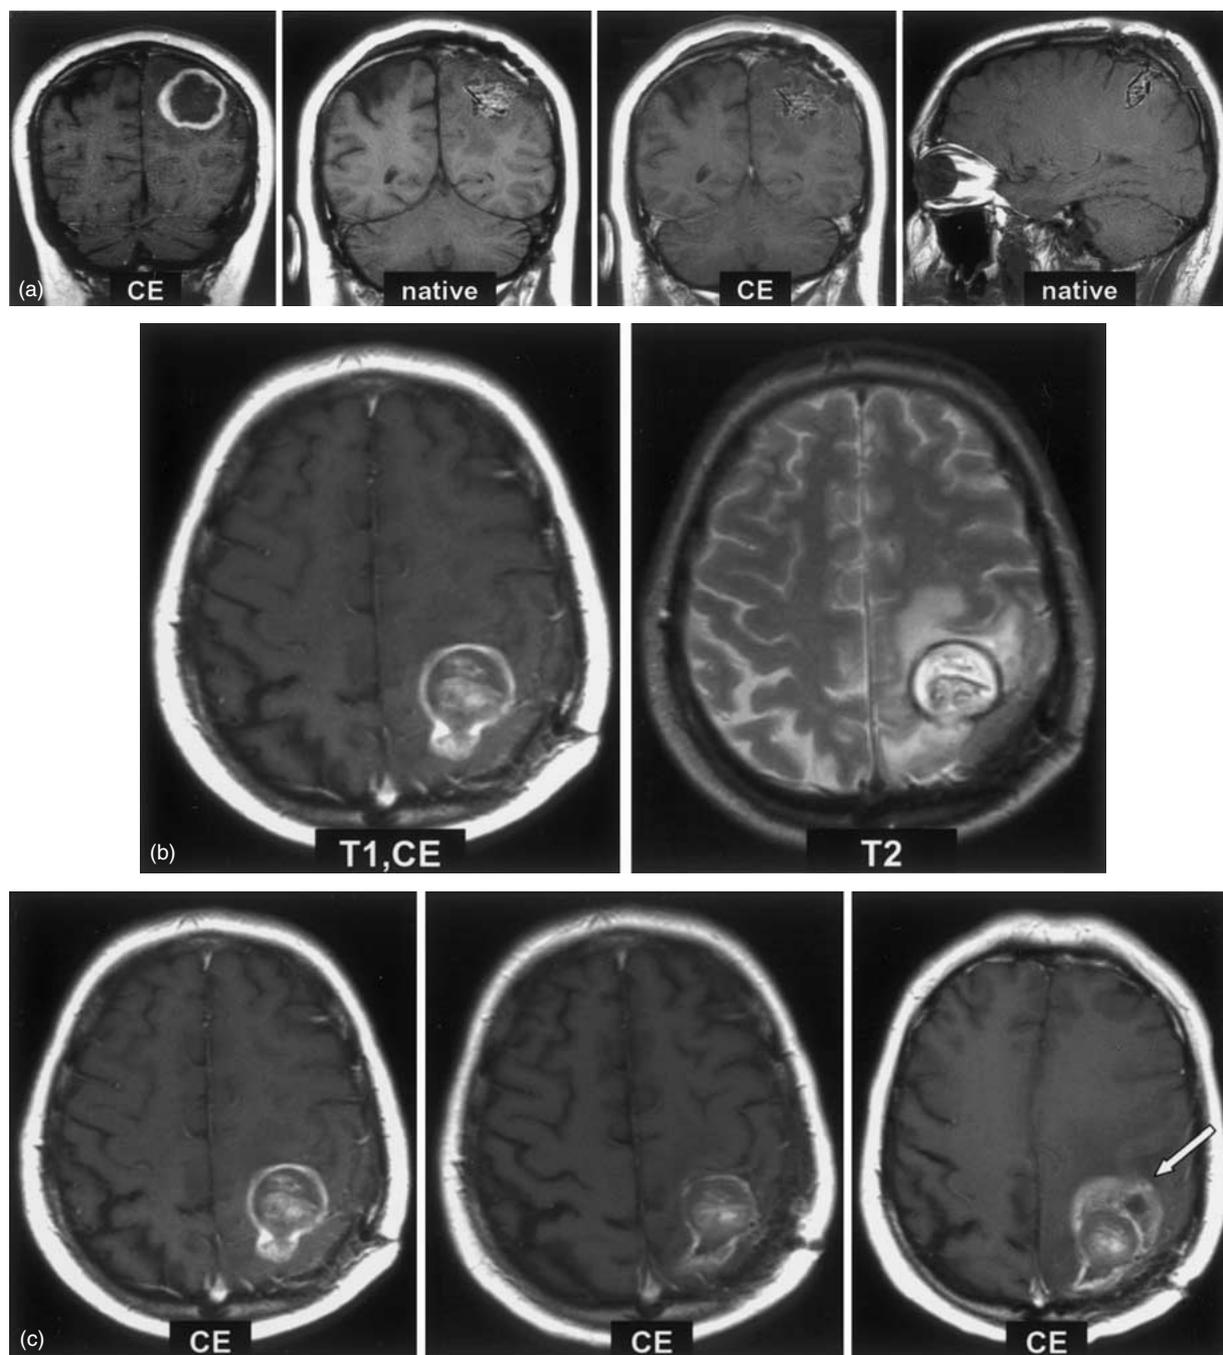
Imaging characteristics of wafer implants on MRI. (a) 45 year-old male diagnosed with a left post central glioblastoma (left image) was randomized to implantation of placebo wafers. Postoperative T1 weighted images show hemorrhagic transformation of the resection cavity without residual enhancing tumor. Wafers are visible as signal free, platelet shaped structures placed adjacent to the resection margins. (b) At 3 months post OP, enhancement of the resection margin is prominent. Remnants of incompletely resorbed blood degradation products and wafer material are noticeable in the center of the cavity, now showing a cystic configuration. Methemoglobin, causing a clear signal decrease, is also located at the resection margins forming a dark ring in the T2 weighted image (right). (c) Time course until tumor recurrence 3, 6, and 8 months post OP (from left to right). At 6 months, enhancement of the resection margin is less prominent and keeps its configuration and size even until local recurrence of the tumor at the rostral margin (arrow) appears.
